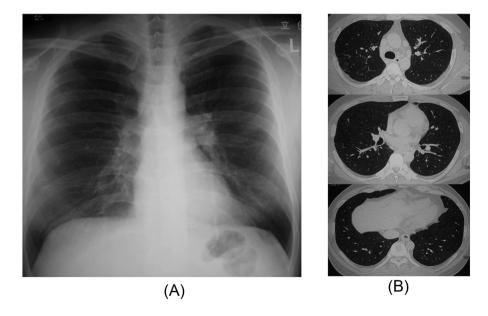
Chest radiologic findings in Case 1. (A) Chest X-ray showed faint nodular shadows in the bilateral lung fields. (B) Chest high-resolution computed tomography shows diffuse fine nodular opacities that were distributed mainly in the upper and middle lung zones with mediastinal lymph node enlargement.
